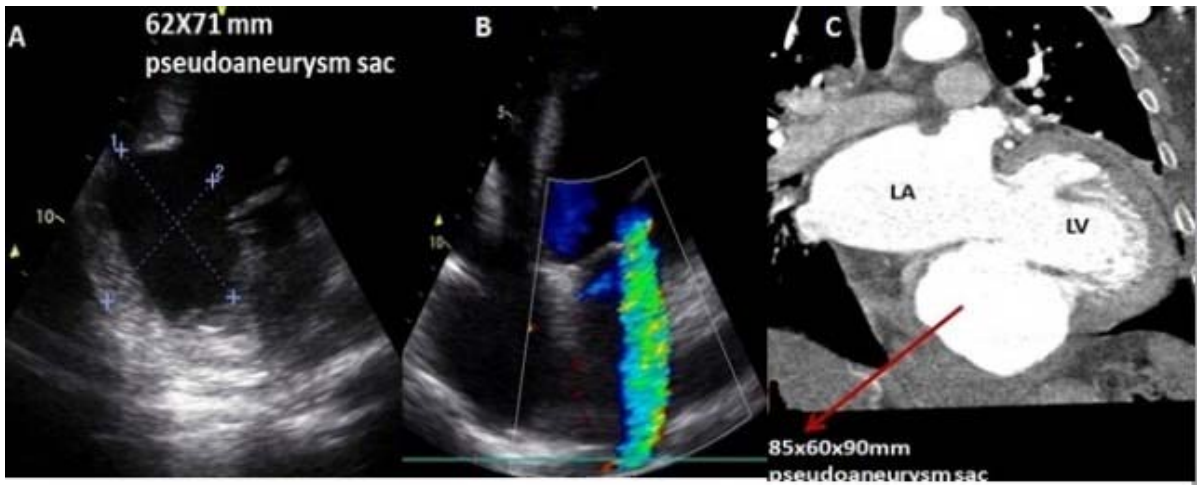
Echocardiographic and Cardiac BT image of pseudoaneurysm of case 2.
